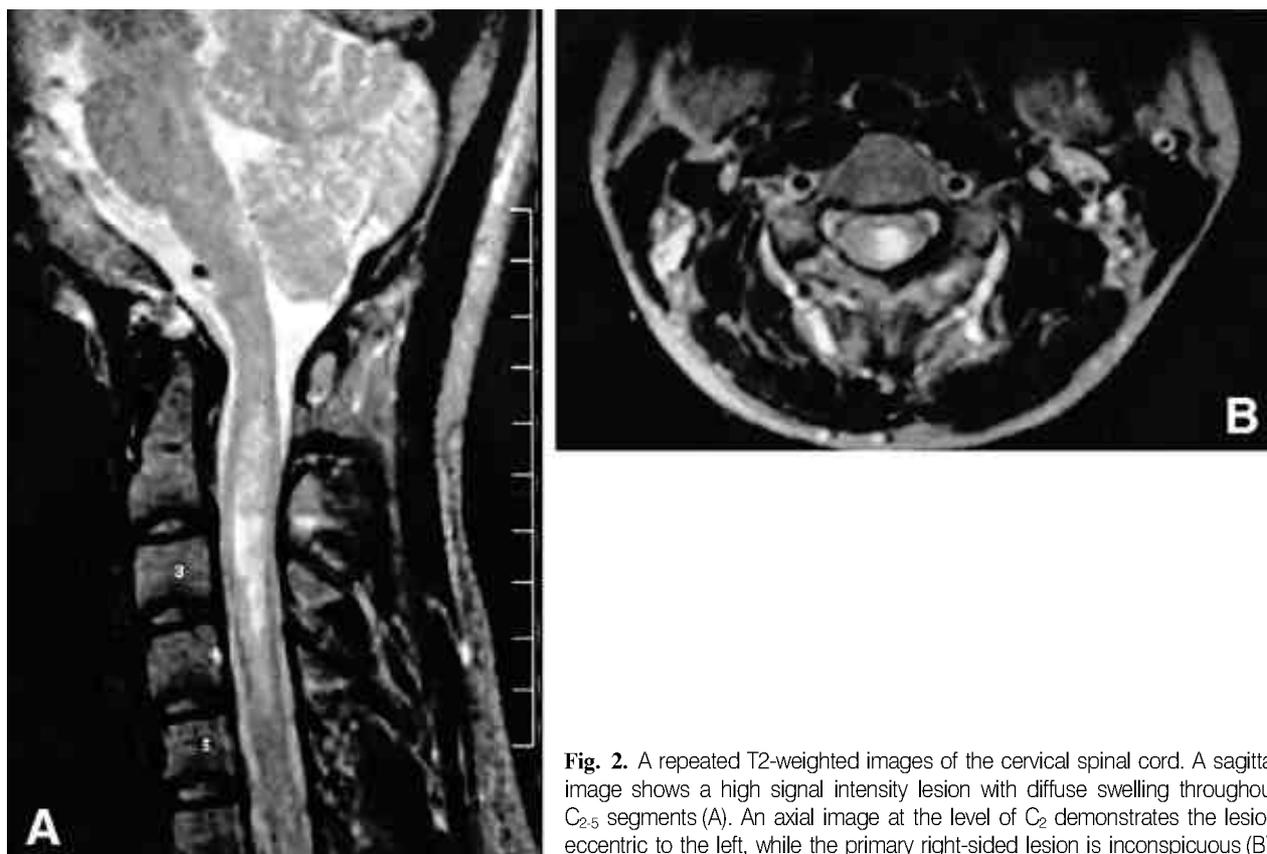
A repeated T2-weighted images of the cervical spinal cord. A sagittal image shows a high signal intensity lesion with diffuse swelling throughout C₂₋₅ segments (A). An axial image at the level of C₂ demonstrates the lesion eccentric to the left, while the primary right-sided lesion is inconspicuous (B).
